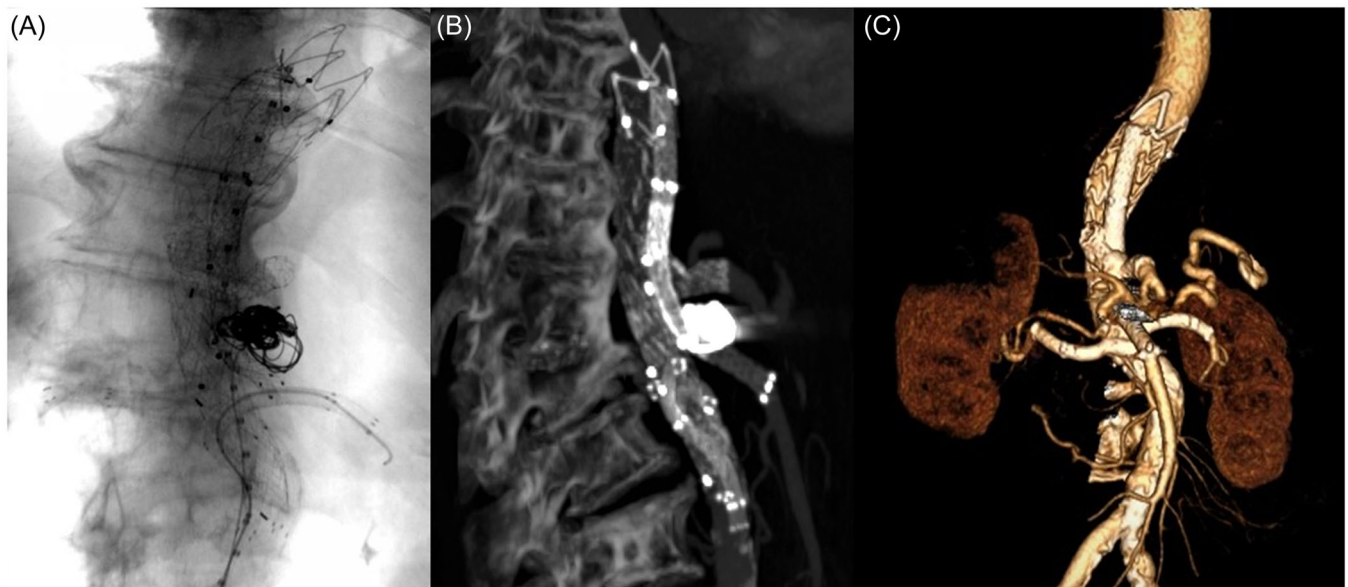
(A) Coils pack embolization and parallel-grafts reconstruction at fluoroscopic view. (B) MIP reconstruction at 6 months computed tomography scan. (C) Volume rendering reconstruction showing pseudoaneurysmal sac exclusion and visceral vessels patency. [Color figure can be viewed at wileyonlinelibrary.com]
